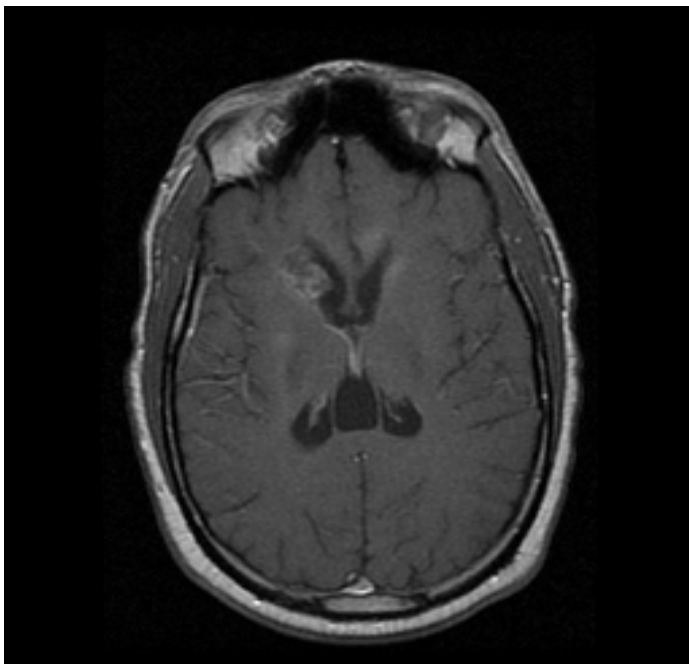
Brain MRI (T1 axial image post gadolinium) showing mass-like heterogeneous enhancement involving the right caudate nucleus.
